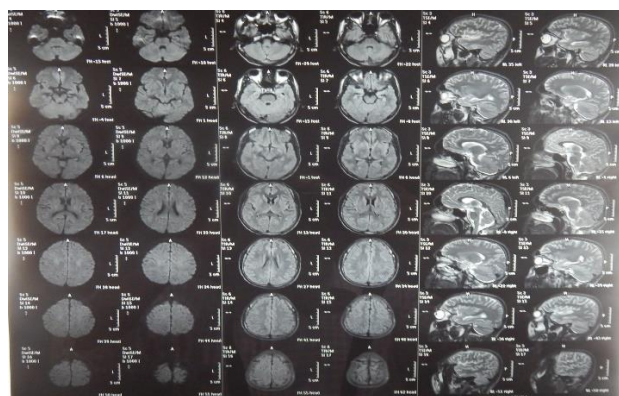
MRI brain screening.
